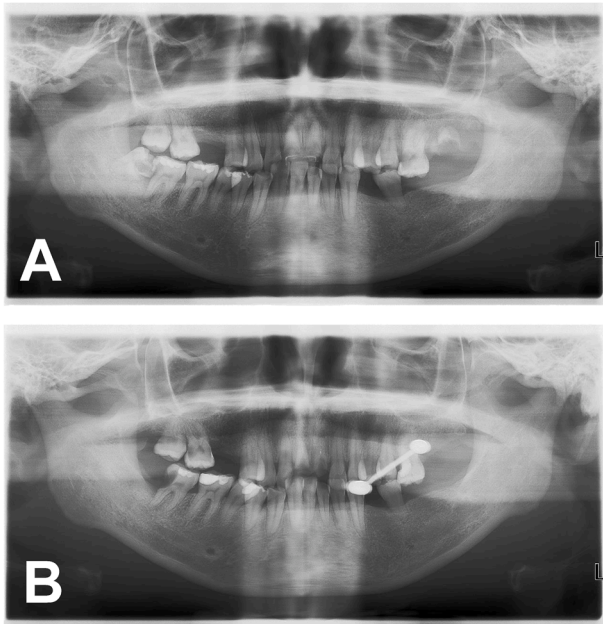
The panoramic radiographs of a 34-year-old female patient without wearing a tongue ring (A) and with wearing a tongue ring (B). The tongue ring was not really a ring but rather a barbell. This body jewelry was made of some kinds of metal material. It might interfere with the radiographic image quality to some extent.
